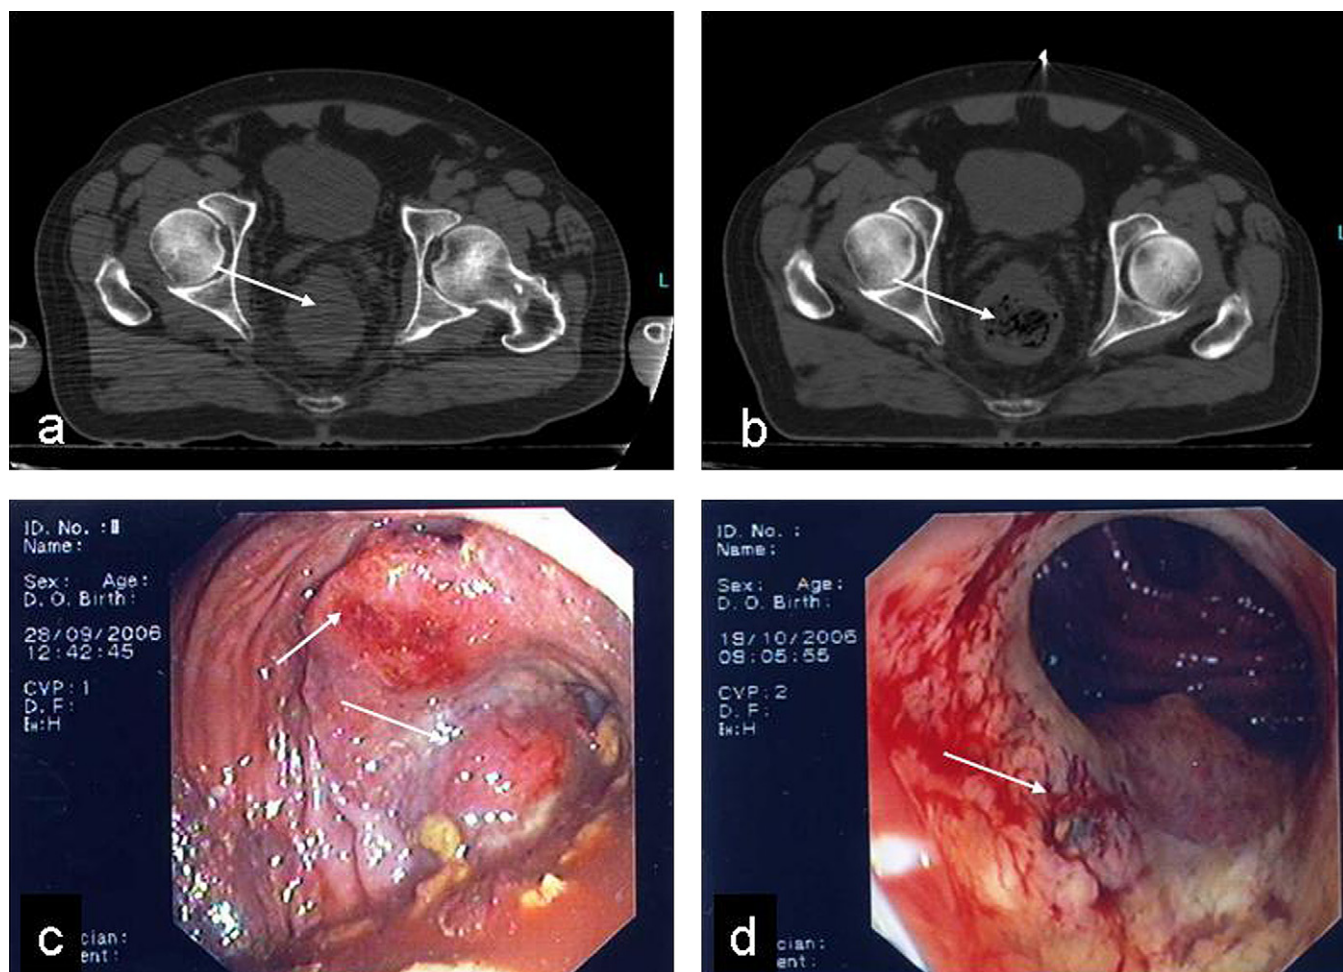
Tumor obstructing the rectal lumen (arrows in a and c) and tumor regression (arrows in b and d) 1 week after bevacizumab-based preoperative radiochemotherapy as confirmed by (a, b) computed tomography scan and (c, d) endoscopy.
